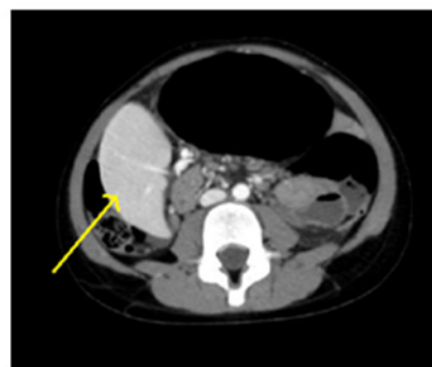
Coronal section of abdominal CT scan.
